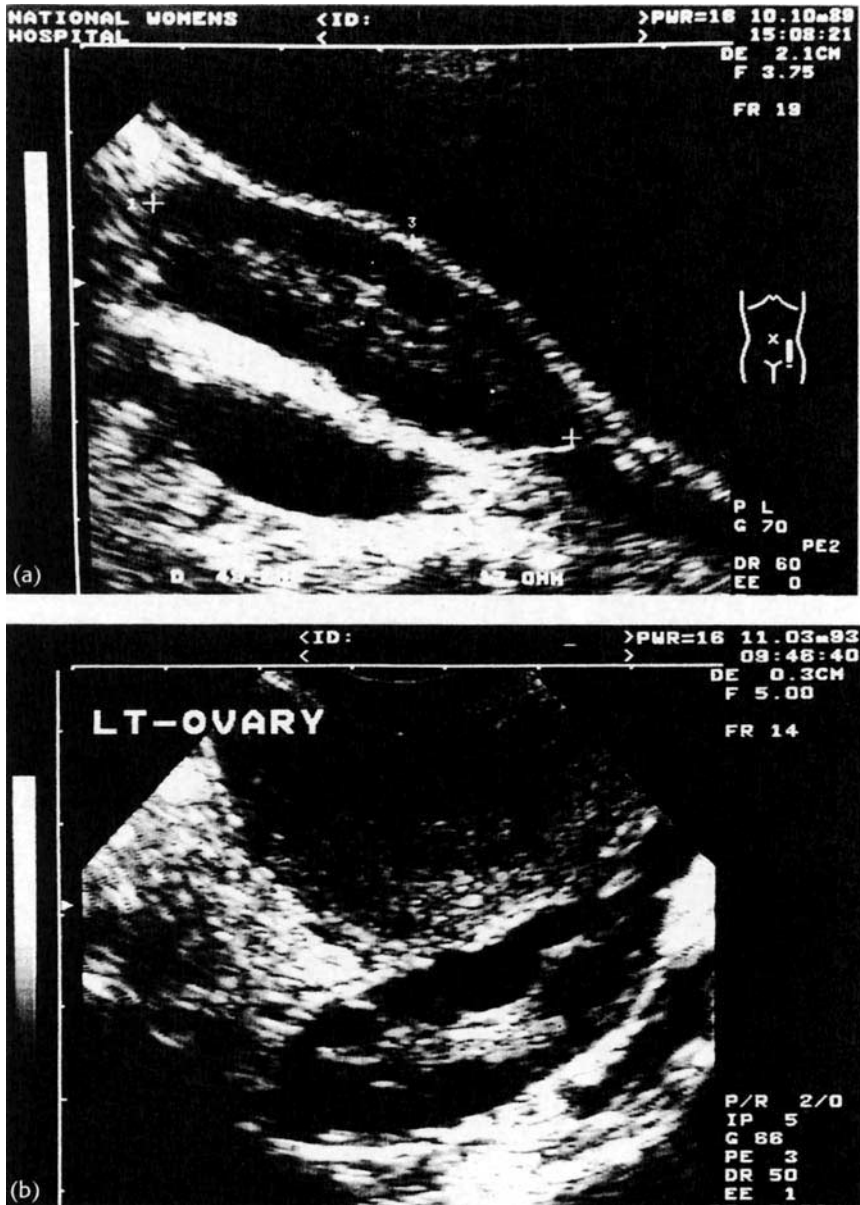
Ultrasound view of polycystic ovary: (a) transabdominal, (b) transvaginal.
